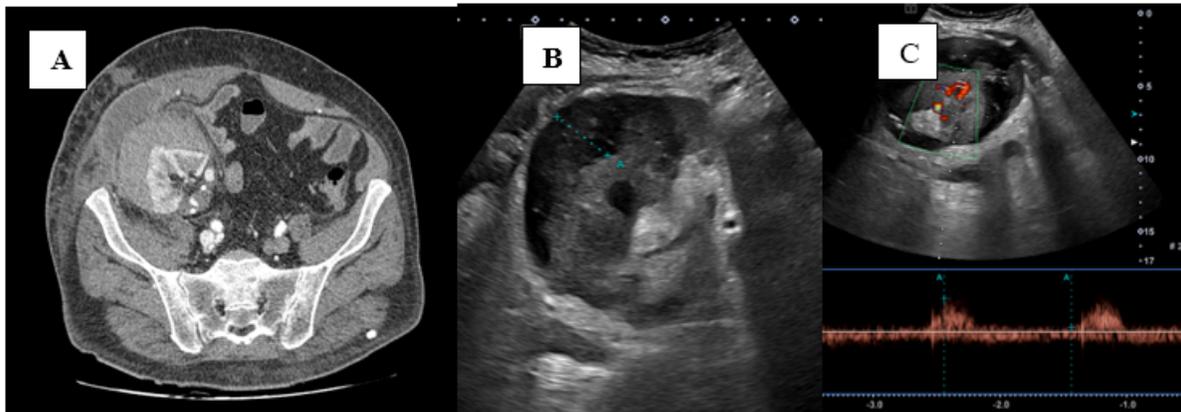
Patient #3 imaging studies. A) Axial computed tomography with contrast after KT. B) Control ultrasound 3 weeks after surgery.
